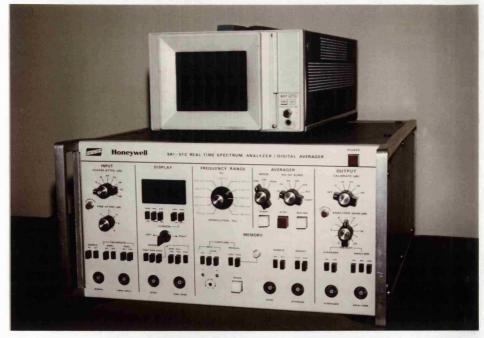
The Sonicaid Doppler unit used throughout the work described in the thesis. Figure 2. The spectrum analyser.
